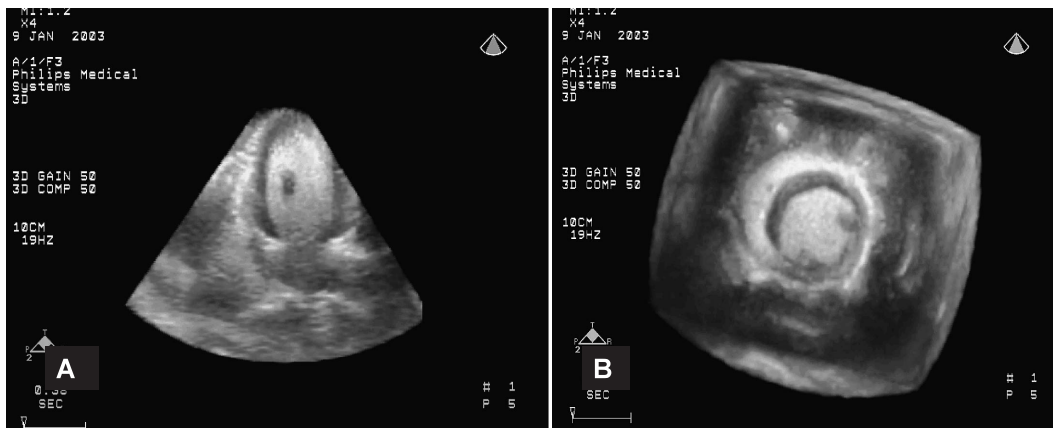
Measurement of left ventricular myocardium volume by real-time three-dimensional echocardiography
